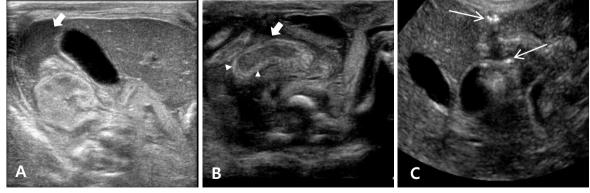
Abdominal ultrasonographic findings suggestive of intestinal perforation in extremely low-birth-weight infants with gasless abdomen on simple abdominal radiography. (A) Fluid collection with heterogenous echogenecities is observed in the extraluminal space (short arrow). (B) Bowel wall thickening (short arrow) and increased intramural echogenicity (arrowheads) are observed. (C) Two tiny echogenic air bubbles are observed in the extraluminal space (long arrows).
